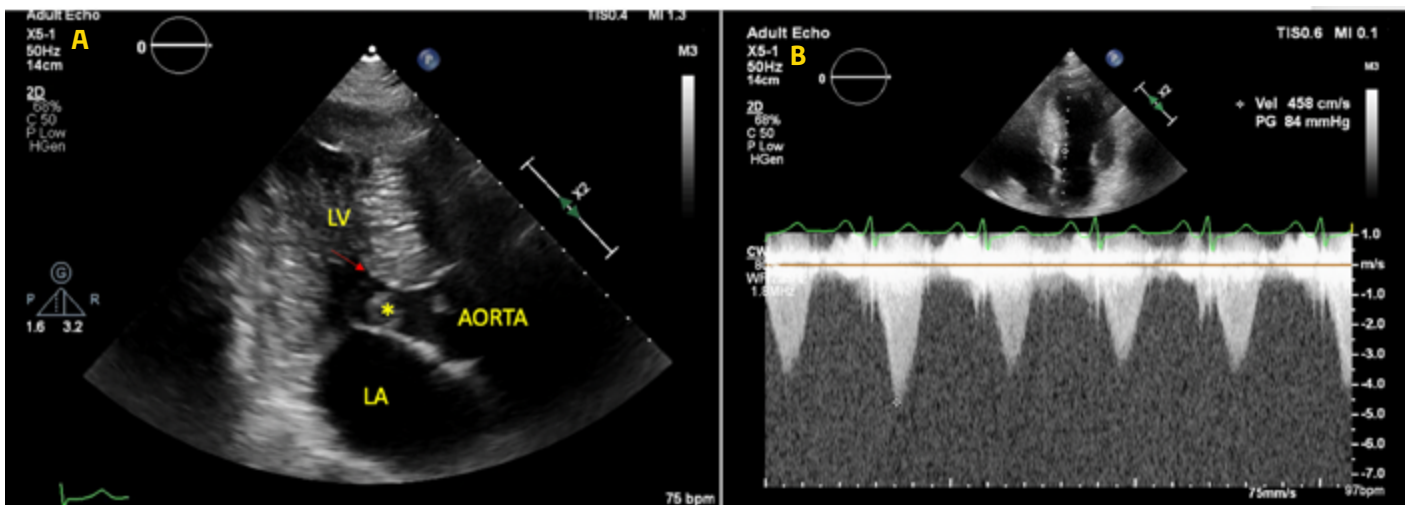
Accessory mitral valve tissue (*) and systolic anterior motion (red arrow) in transthoracic echocardiography apical 3-chamber view (A) and left ventricular outflow tract gradient with a maximum of 84 mmHg measured by continuous-wave Doppler (B) (LA, Left Atrium; LV, Left Ventricle).
